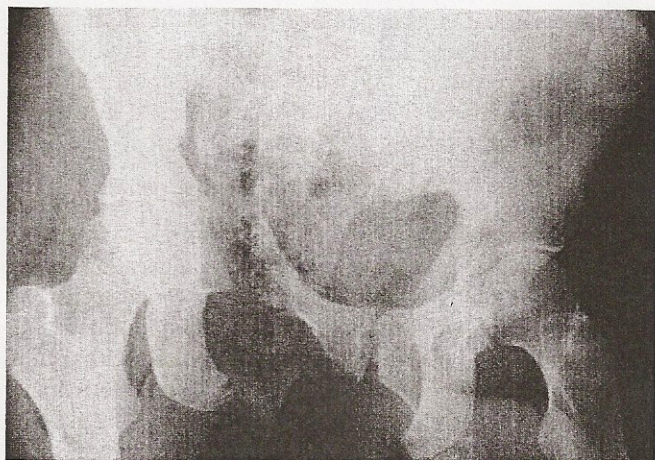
Initial anteroposterior pelvis radiograph showing a complete right sacroiliac joint dislocation with cephalad migration of the right hemipelvis. The left sacroiliac joint is disrupted anteriorly, and bilateral superior and inferior pubic rami fractures were noted with associated air densities in the soft tissues.
